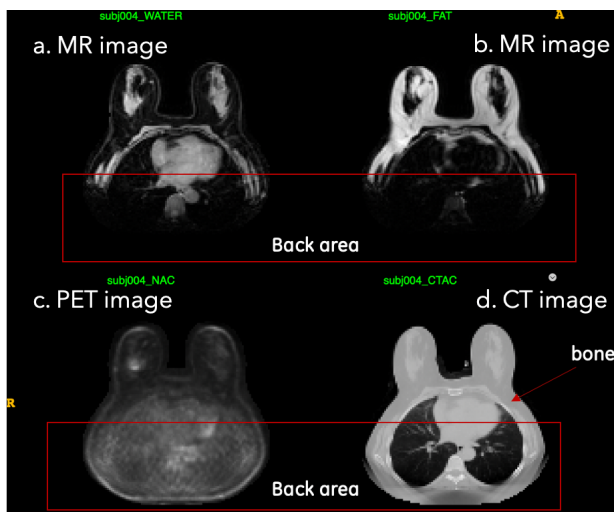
Comparison of MR images, PET image and CT image of the breast part. a) and b) are two MR images of water and fat components. Apparently the MR images have problems of missing bone and back truncation.
